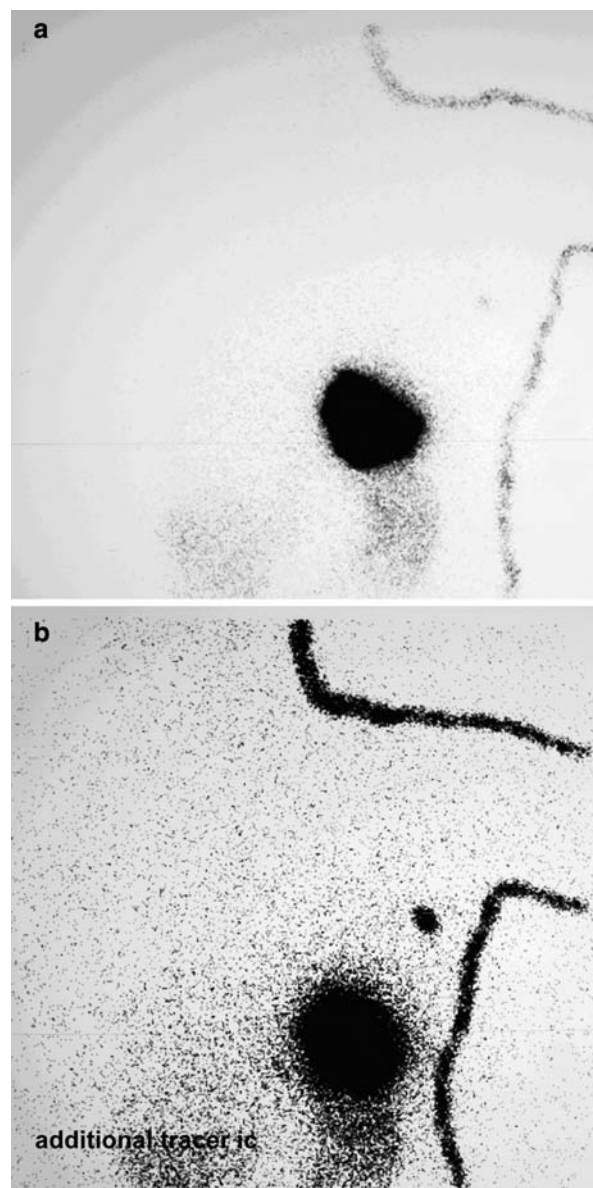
Lymphoscintigraphy of patient with faint hotspot (a), but clear hotspot after additional tracer injection (b)
